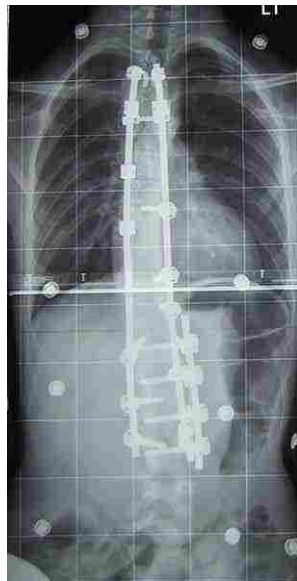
X-Ray View of Thoracic Fusion [34]
